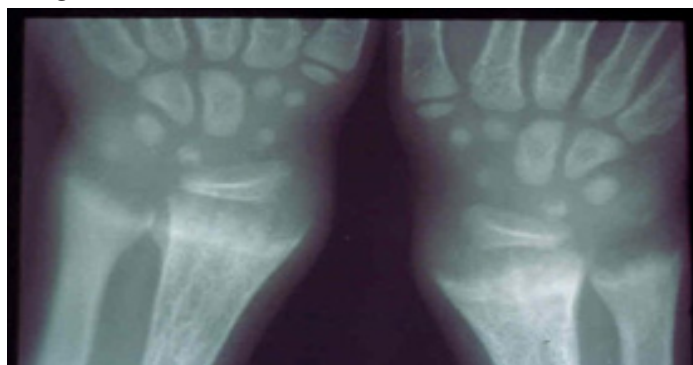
Typical Wrist X-Rays of Rachitic Child demonstrating wide, frayed, cupped epiphyses
